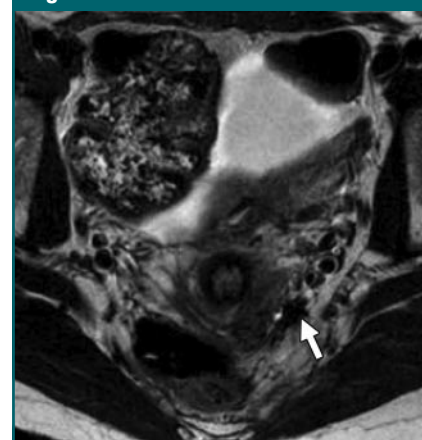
Axial high-spatial-resolution TSE T2-weighted flow-compensated MR image (repetition time, respiratory period; echo time, 135 msec) shows left USL involvement (arrow) in 24-year-old woman; this lesion was the false-negative instance of the diagnosis of deep endometriosis in our series and was seen retrospectively.
